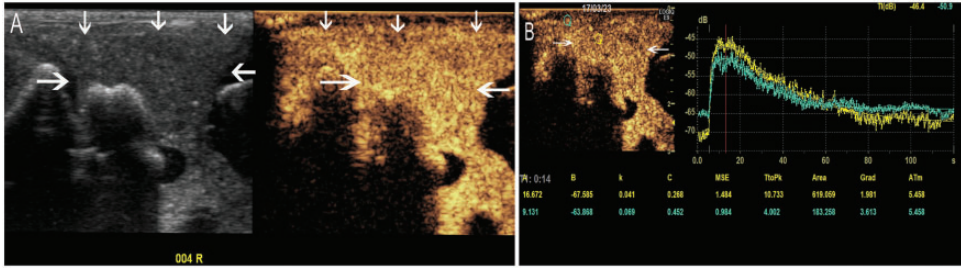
(a) Real-time grayscale contrast-enhanced ultrasound (CEUS) (real-time double side-by-side image display). Two-dimensional ultrasound on left showing synovial hyperplasia in the antigen-induced arthritis (AIA) group; CEUS on the right showing enhanced synovial membrane in the AIA group. (b) CEUS region of interest (yellow) was selected to obtain the time-intensity showing a fast-in/slow-out pattern, and quantitative parameters. Arrows indicate synovium.
